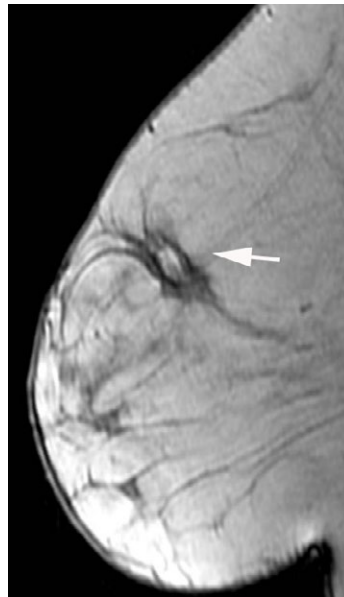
MASS INTERNAL ENHANCEMENT: RIM: T1 weighted image without fat suppression on MRI shows fat in the mass (arrow). This is a typical benign finding at a lumpectomy site with fat necrosis.
